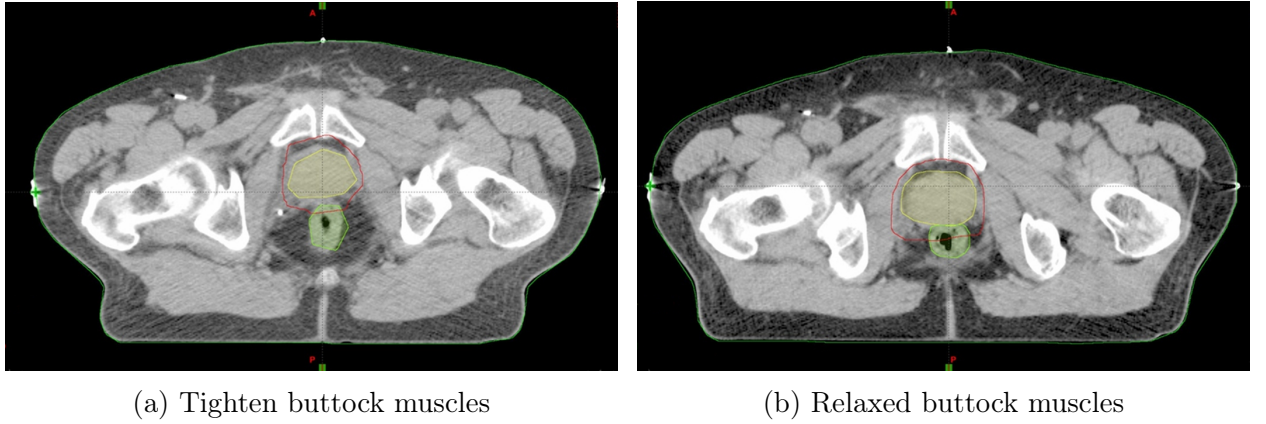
Comparison of two CT slices of the same patient. On the left the situation in which muscles' tension can be observed. On the right — relaxed muscles. The change in the PTV position (red line) can be observed — PTV is higher in regard to table top while muscles are tighten. GTV is shown as a yellow region while rectum is a green one.
